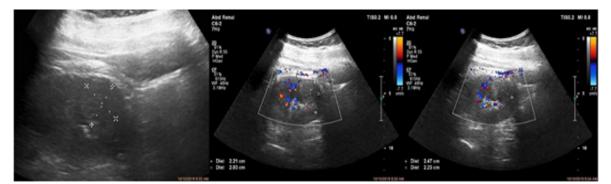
Follow up Sonographic view of the case of pseudoaneurysm which was managed conservatively.
